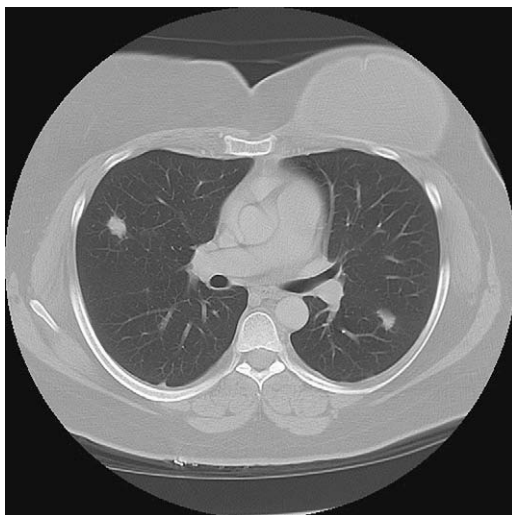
A high-resolution chest CT with lung windows. Large bilateral soft tissue nodules without evidence of cavitation. Multiple nodules on other images are not shown. Nodules resolved completely when patient was treated with corticosteroids.
